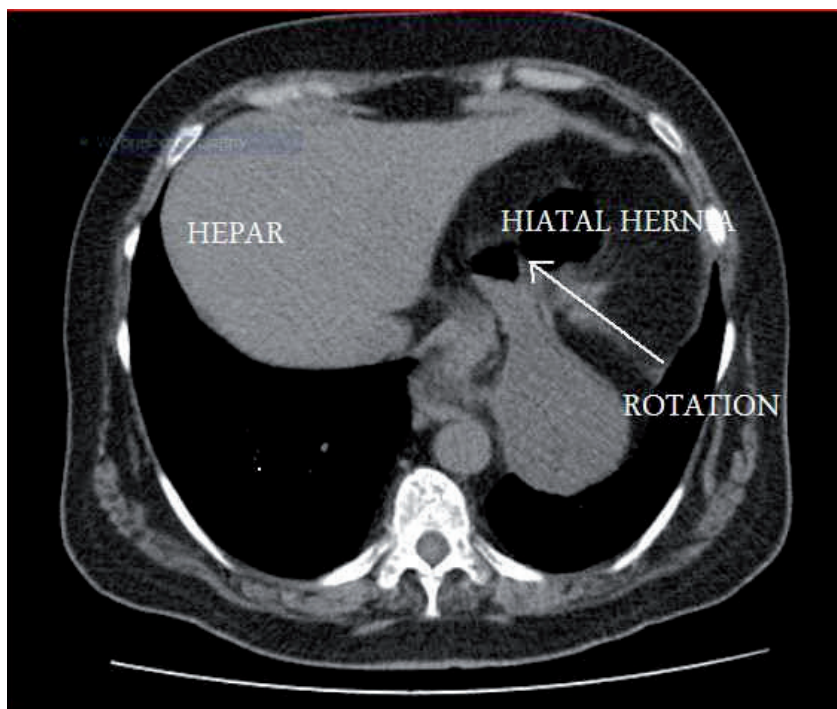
Computed tomography scan of the upside-down stomach.
